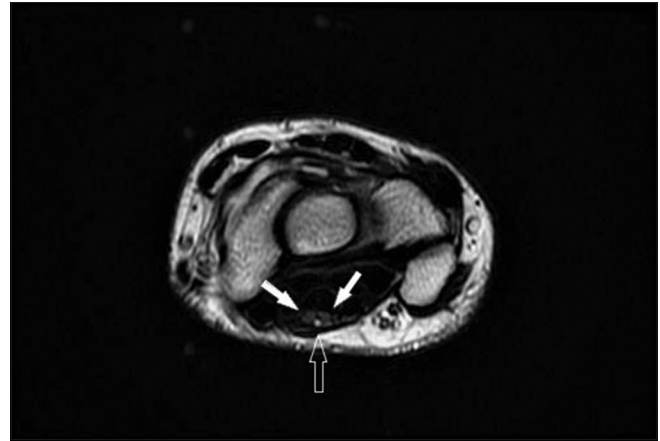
T2-weighted axial image represent a persistent median artery (open arrow) pierces through bifid median nerve (arrows)
